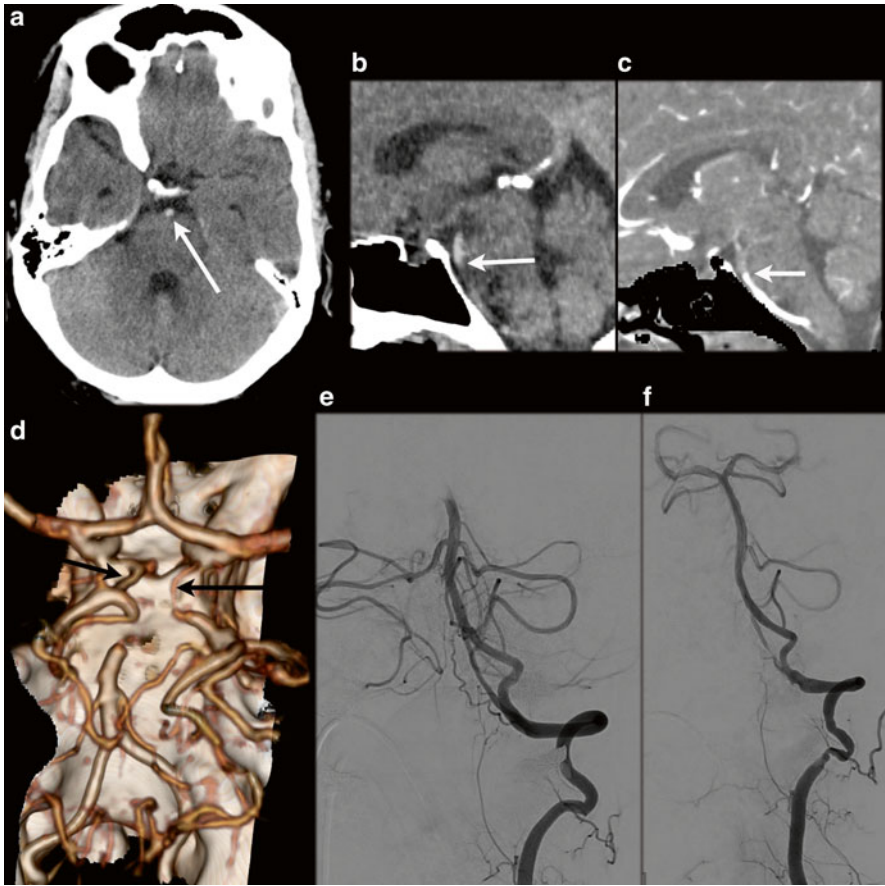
A 46 y/o male presented with left-sided hemiparesis and dysarthria after ablation procedure for atrial flutter. NECT shows normal density and normal gray-white matter differentiation. A dense artery sign is present in the distal basilar artery (a, *white arrow*), suggestive of basilar artery occlusion. Subsequent CTA confirms an occlusion of the distal basilar artery (b: sagittal NECT, c: CTA sagittal MPR), matched images. 3D VR (d) shows the occluded distal basilar artery; there is collateral blood flow to the P2 segments via de bilateral Pcoms (*black arrows*). DSA confirms the occlusion (e) and intra-arterial thrombectomy was performed with successful recanalization (f). After 3 months only mild balance disturbances were present
